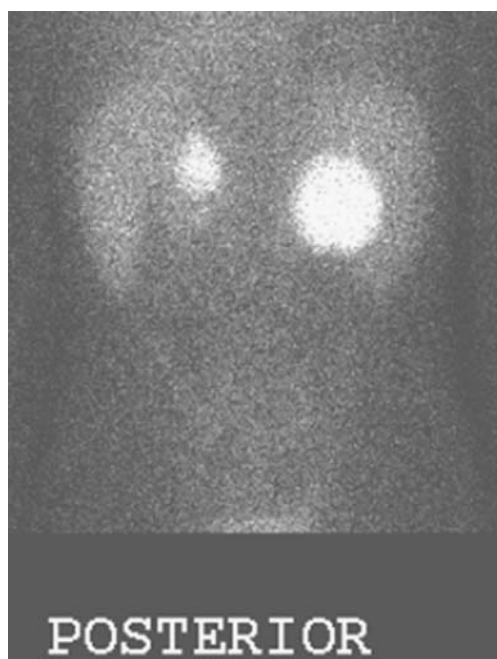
Functional imaging. Tc-99m-DMSA renal scintigraphy (posterior projection) demonstrates marked uptake of the radiotracer in a distribution corresponding to the masses depicted on CT, MR, and US scans. Here, functional imaging reveals the “masses” depicted by the other modalities to be functional renal tissue
